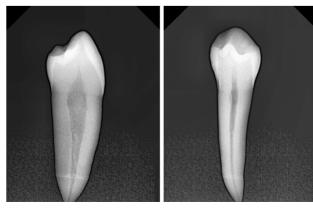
Buccolingual and mesiodistal radiographs.
